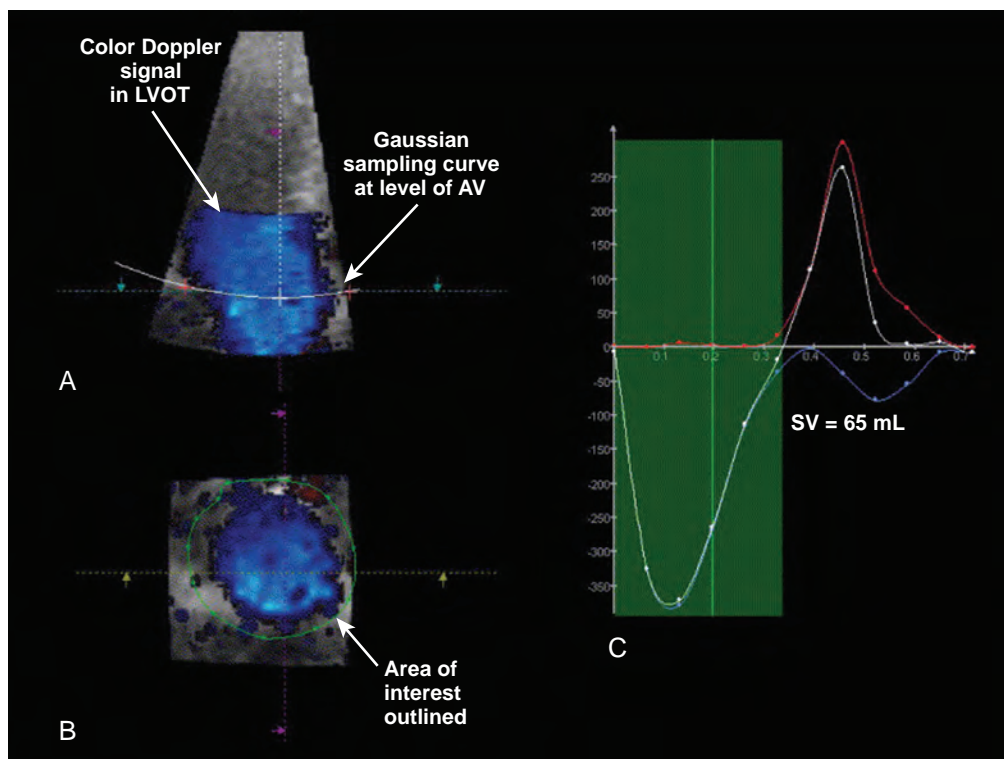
Calculation of flow using Gaussian control surface theory. (A) One of two orthogonal cut planes of real-time three-dimensional Doppler echocardiographic volume with sampling curve placed at the level of the aortic valve (AV). (B) Third plane as if viewed from left ventricular cavity, with the region of interest, Doppler signal within left ventricular outflow tract (LVOT), outlined. (C) Flow rate-time curve generated by integration of Doppler signals within the region of interest, at level of sampling curve, over course of systole (green). SV, Stroke volume. (Reproduced with permission from Pemberton J, Ge S, Thiele K, et al. Real-time three-dimensional color Doppler echocardiography overcomes the inaccuracies of spectral Doppler for stroke volume calculation. *J Am Soc Echocardiogr.* 2006;19:1403–1410).
